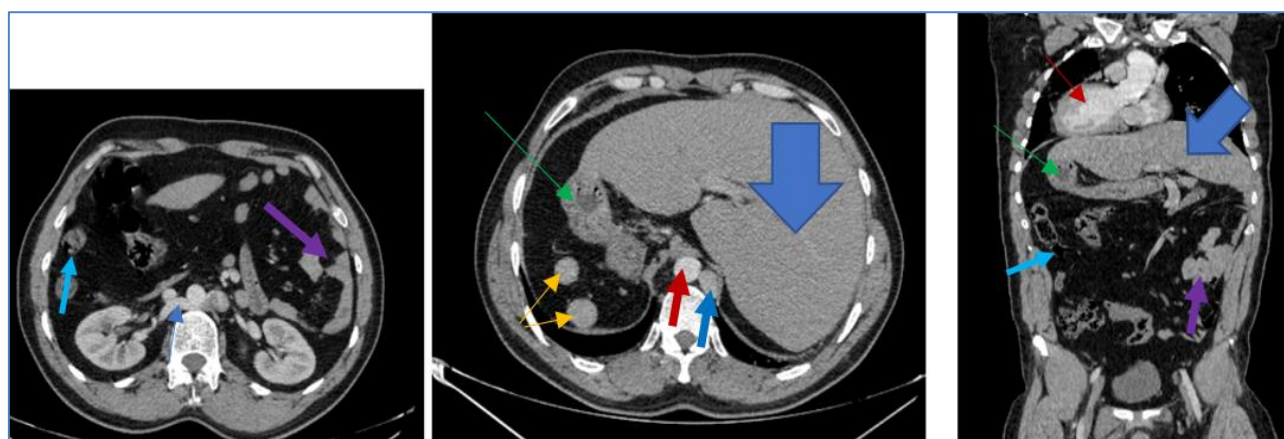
c: Abdominopelvic CT scan axial and coronal section with injection of non-ionic iodinated contrast medium: total situs inversus, liver on the left, stomach and polysplenia on the right; inferior vena cava on the left of the aorta, retro aortic renal vein, as well as the colonic frame on the right and small intestine on the left
